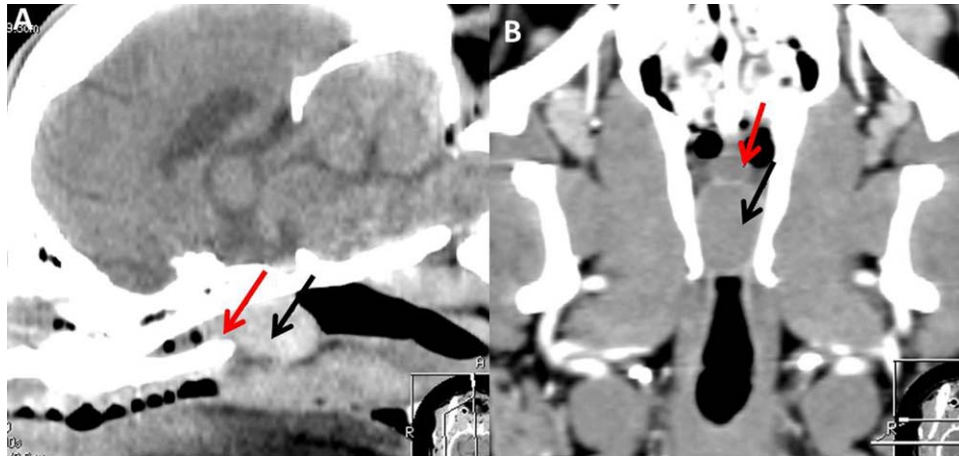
Midsagittal (A) and dorsal (B) computed tomograms from a Pug with multiple ventral obstructive nasopharyngeal sialoceles (case 9). A small cyst-like lesion was present at the end of the hard palate (red arrow), and a large lesion was located dorsal to the soft palate (black arrow)
